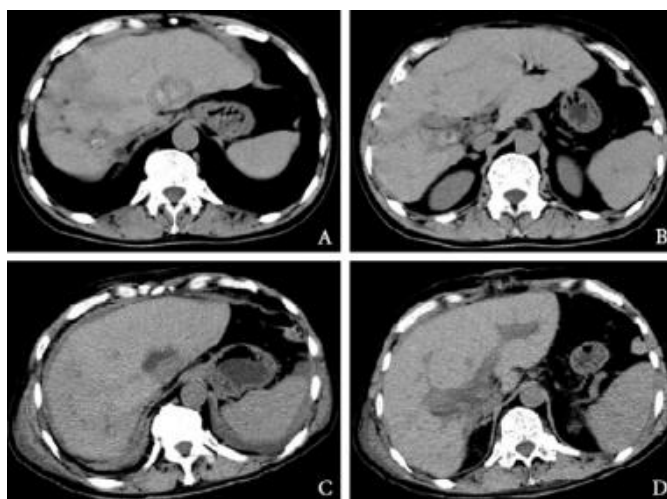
A, B: abdominal CT showing a lot of stones located in the bilateral intrahepatic bile duct before laser lithotripsy; C, D: abdominal CT showing no intrahepatic bile duct stones after laser lithotripsy.
